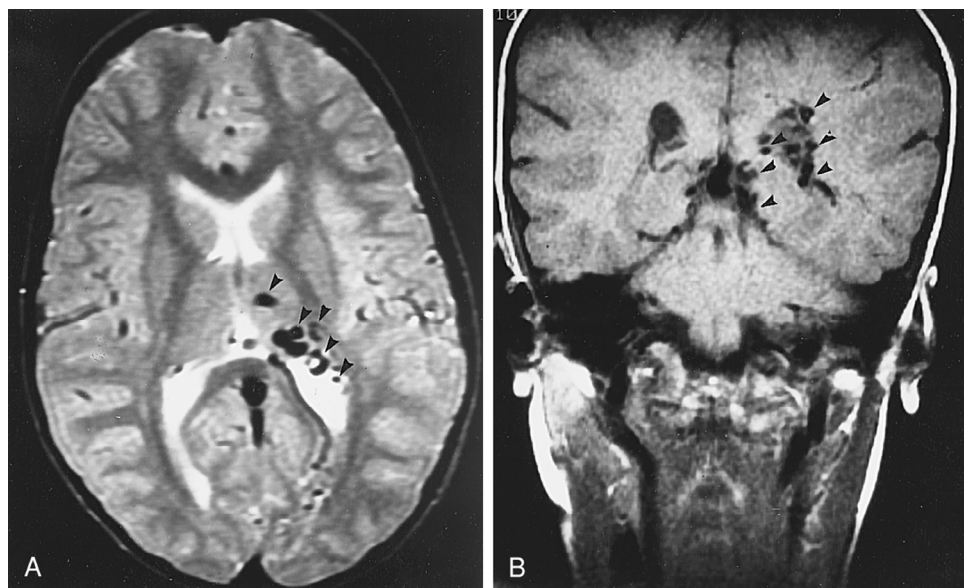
Cranial magnetic resonance imaging scan of a 6-year-old girl with recurrent headache. A, Axial view demonstrates flow voids deep in the left hemisphere near the lateral ventricle (arrowheads), consistent with arteriovenous malformation. B, Coronal view through parietal lobes also demonstrates numerous flow voids (arrowheads) indicative of arteriovenous malformation.
